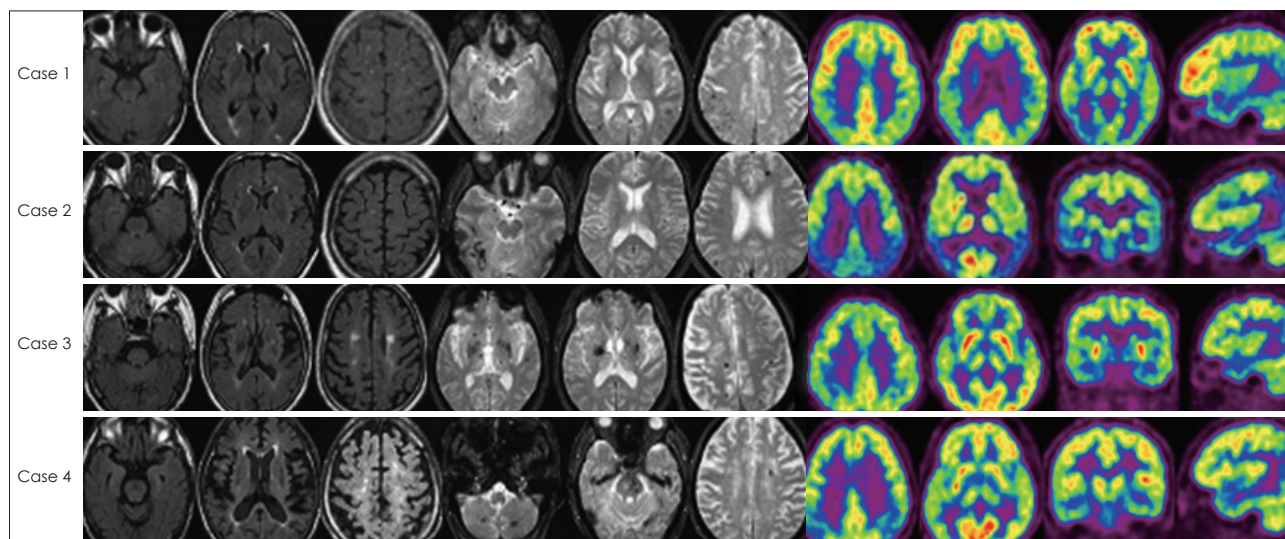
Axial fluid attenuated inversion recovery scan and gradient-recalled echo magnetic resonance imaging scan of the brain and positron emission tomography of the brain.
